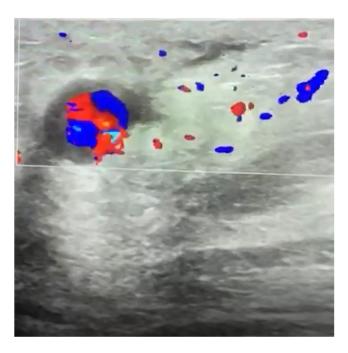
Color Doppler image of the right breast mass showing swirling (yin yang) flow within the pulsatile anechoic center of the lesion.
